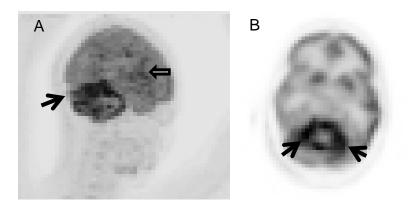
Maximum intensity projection (A) and axial image (B) from <sup>18</sup>F-FDG PET showing increased leptomeningeal radiotracer uptake of the cerebellum (arrows) and temporal lobe (open arrow).
